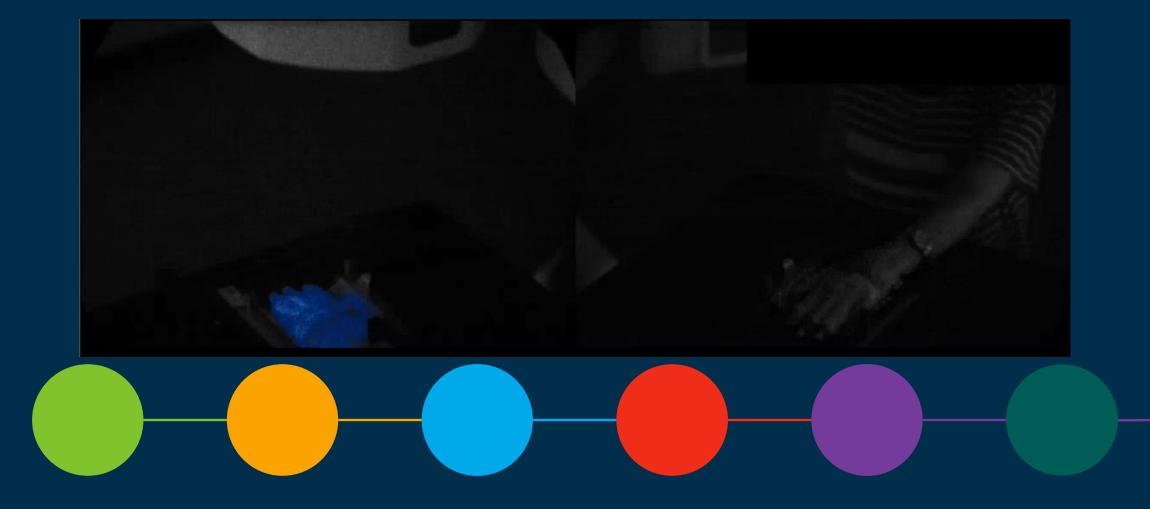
Image and deliver the treatment as planned using the synthetic CT.
